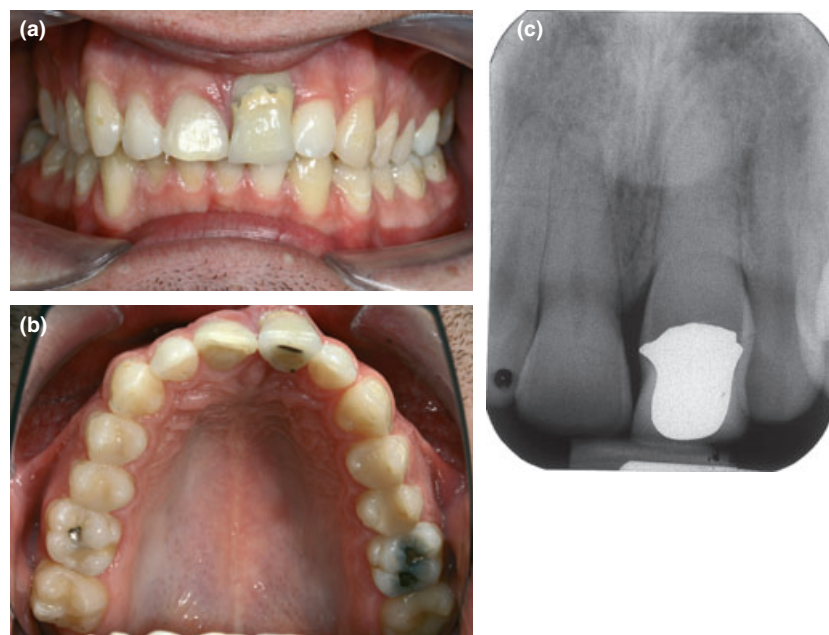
(a, b) Intraoral views of the 23-year-old patient before the beginning of orthodontic treatment. Note the clearly inadequate crown restoration of infrapositioned tooth 21. (c) Periapical radiograph taken after spontaneous re-eruption of the tooth 21. A periodontal gap is remarkable.
